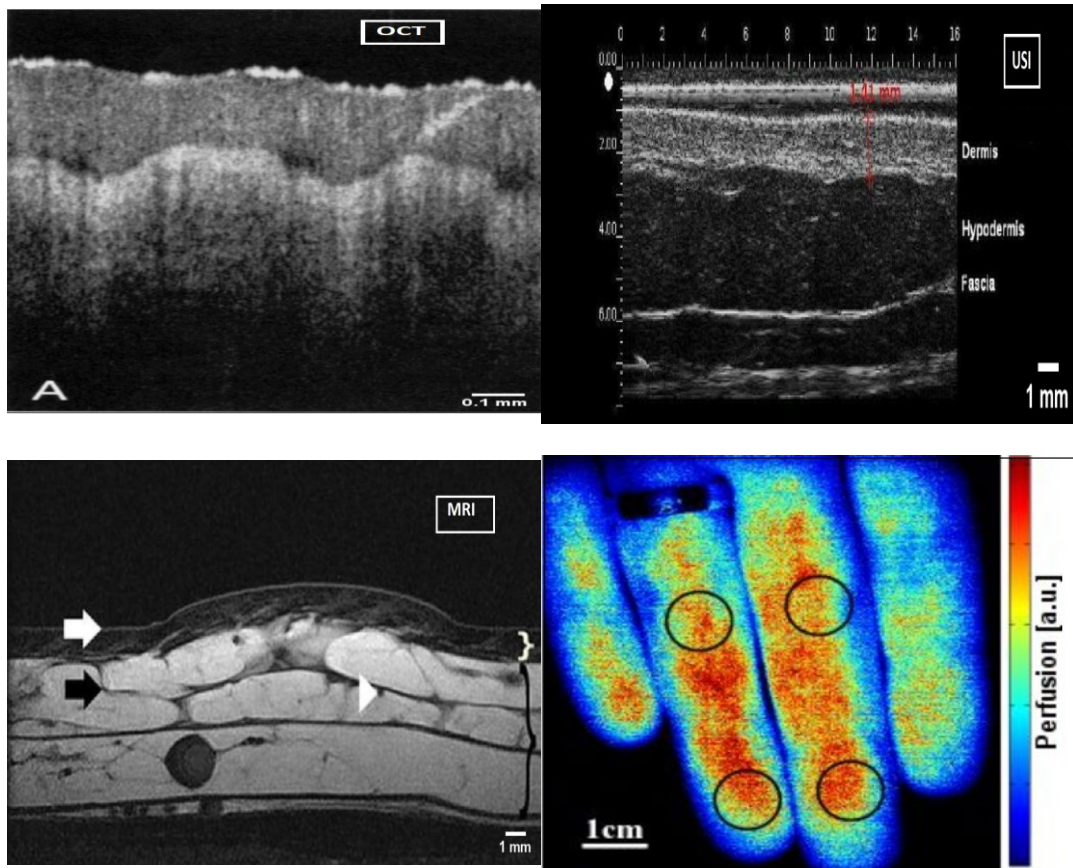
Prominent skin imaging modalities (Clockwise from top-left) OCT: Optical coherence tomography (Cross sectional view); USI – Ultrasound imaging (Cross sectional view); LDI – Laser Doppler perfusion imaging (Top-view) ; MRI: Magnetic Resonance Imaging (Cross sectional view); Adapted from (Welzel, Lankenau et al. 1997, Stefanowska, Zakowiecki et al. 2010, Leutenegger, Martin-Williams et al. 2011, Wortsman 2012, Navarini, Meier et al. 2013)
